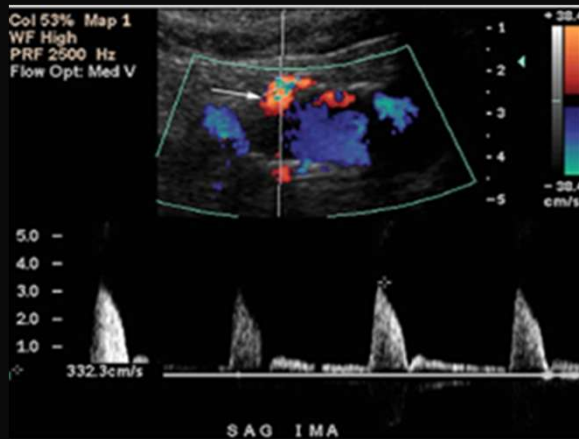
11. Pellerito JS, et.al. Doppler sonographic criteria for the diagnosis of inferior mesenteric artery stenosis.
